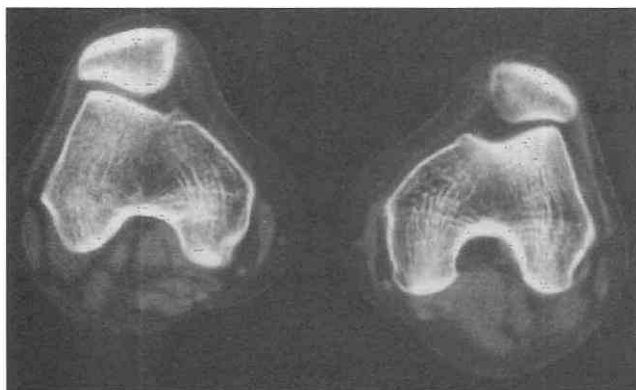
Patellofemoral instability. Axial CT images of the patellar femoral joints show bilateral patellofemoral subluxation. Note the medial and lateral retinacula, neither of which appears taut.
